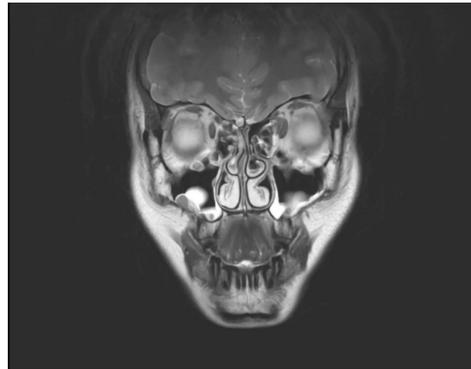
MRI demonstrating T2 heterogenous enhancing lesion of the left medial orbit with displacement of the medial rectus muscle and contact with the globe.
